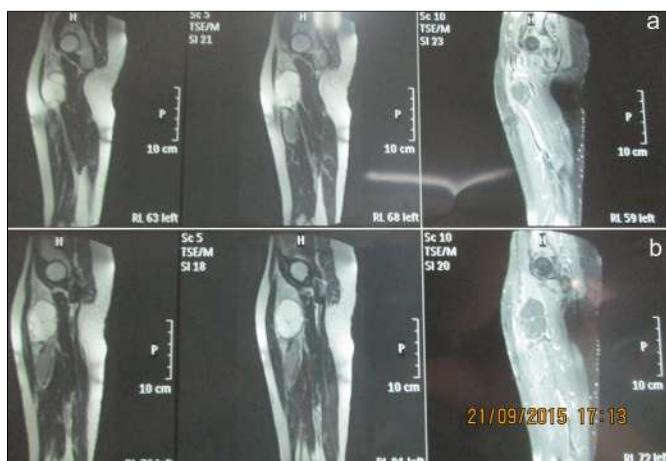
MRI appearance of the lesion: (a) axial view, (b) sagittal view.
